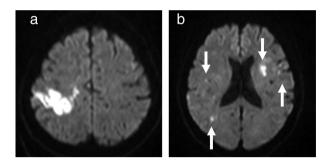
Magnetic resonance imaging (MRI) findings on admission. (a) Diffusion MRI showed a high intensity area in the right cerebral lobe. (b) Small multiple high-intensity areas were observed in the bilateral cerebral lobes (arrows).
